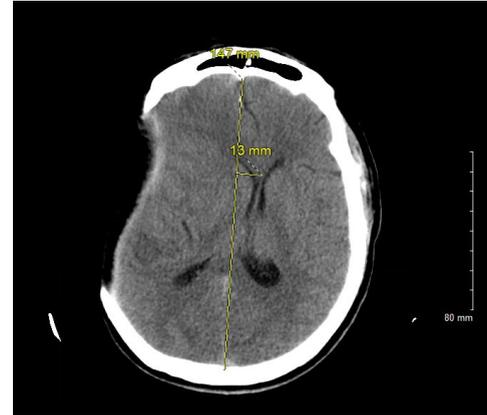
CT demonstrating a 13mm leftward midline shift with subfalcine and right uncal herniation.
